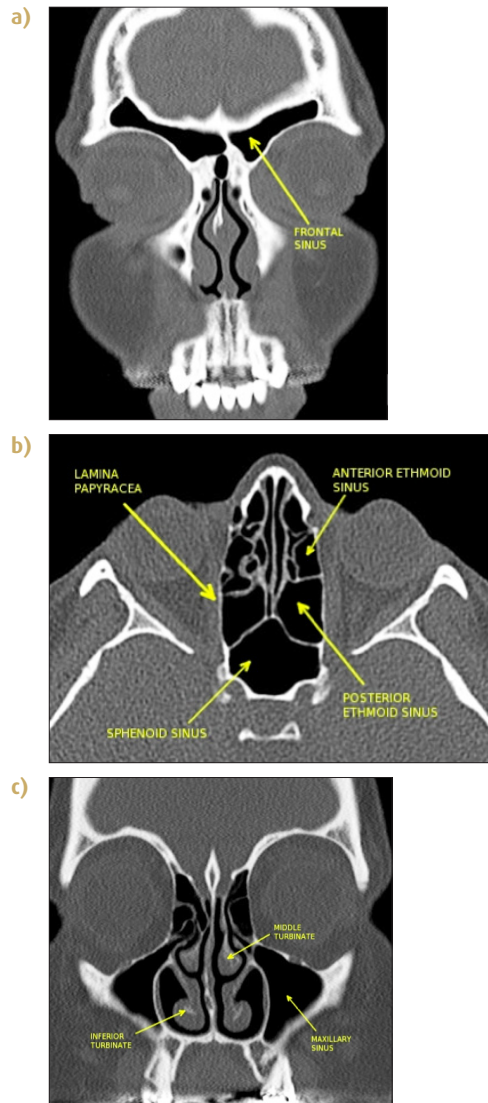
Frontal (a), ethmoidal (b) and maxillary (c) sinuses as shown on computerised tomography (CT)
